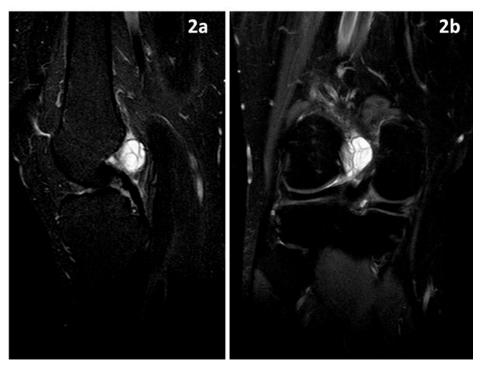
STIR MRI image shows cruciate ganglion cyst adjacent to the cruciate ligament.
